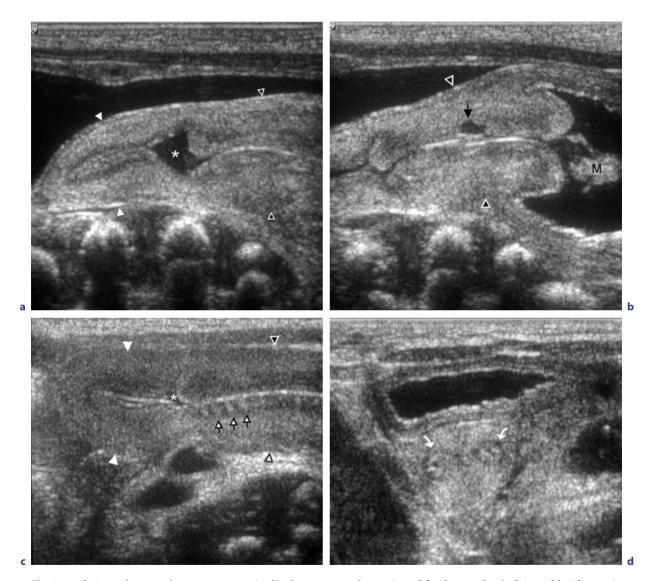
Normal neonatal uterus. a–c Longitudinal sonograms: the cervix and fundus are clearly discernible. The cervix (open arrowheads) has a greater diameter and length than fundus (closed arrowheads). There is a small amount of fluid within the endometrial canal at the junction of fundus and cervix (asterisk). Single nabothian cyst in the cervix (closed arrow). The inner layer of myometrium is hypoechoic (subendometrial halo). Echogenic endometrial glands (open arrows). In the fluid-distended vagina cervical mucus adherent to the vaginal part of cervix is visible (M). d Transverse scan at the level of the fundus shows the uterine horns (area where the tubes enter the uterus; curved arrows)
